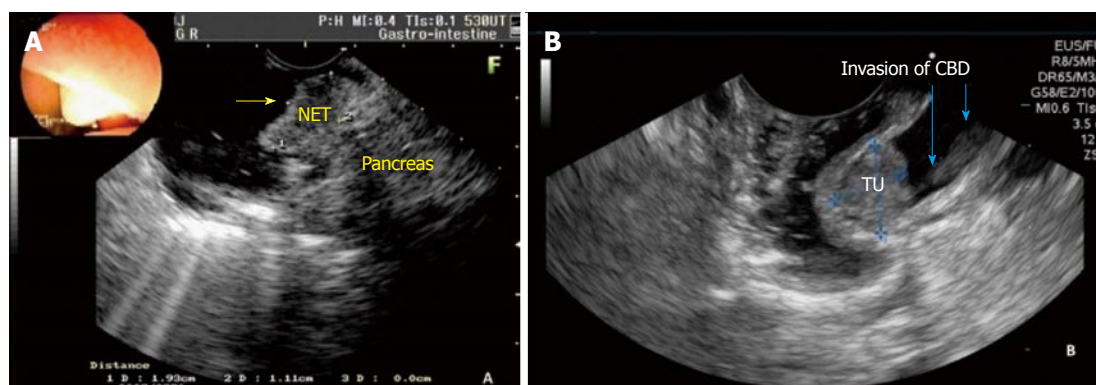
Endoscopic ultrasound staging of the duodenal papilla. A: Patient of the Figure 1. Endoscopic ultrasound staging shows the regular and hypoechoic nodule (1.93 cm) in the papilla without infiltration of the duodenal wall and pancreatic gland. The staging was uT1N0Mx; B: This picture shows the papillary tumor with 1.72 cm with invasion of the common bile duct wall (blue arrows). NET: Neuroendocrine tumor; TU: Tumor; CBD: Common bile duct.
